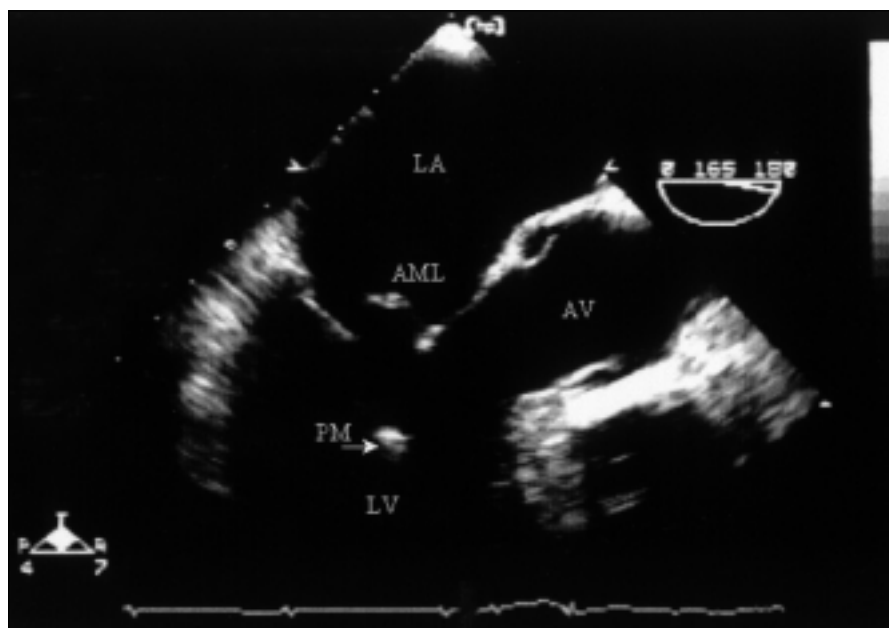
Transesophageal echocardiogram of ruptured papillary muscle head (PM), seen as a mobile echo mass in the left ventricle (LV) during systole. Partial flail of the anterior mitral leaflet (AML) into the left atrium (LA) is also demonstrated. (AV, aortic valve.)
